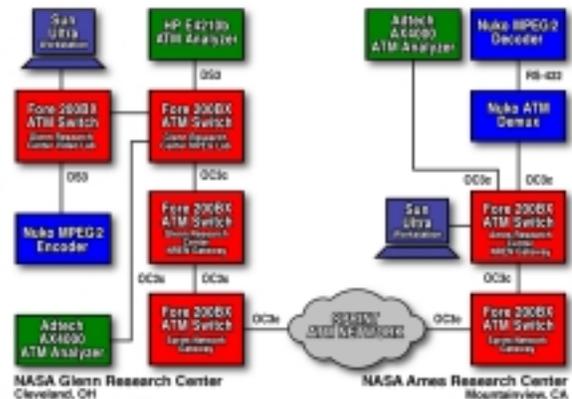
Echocardiographic data across NREN test configuration
